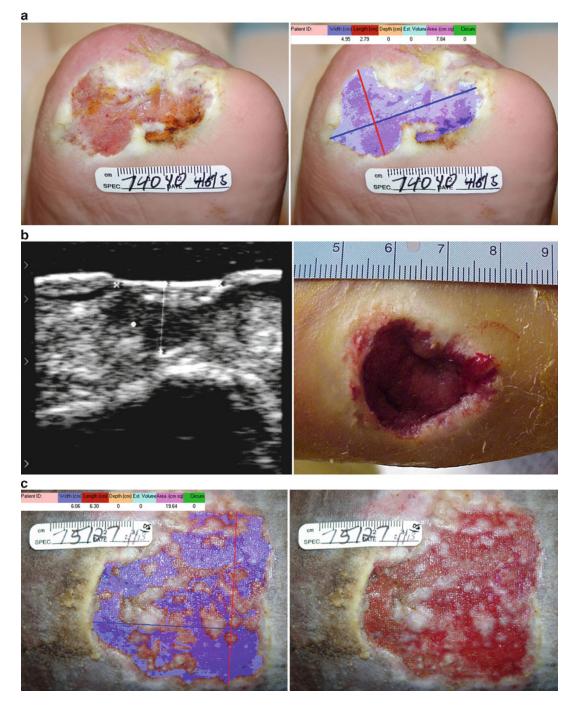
(a) Neuropathic foot ulcer measured on digital photographs using digital planimetry software. (b) High resolution ultrasonography provides noninvasive, objective, accurate measurements for deeper wounds and allows for examination of undermining and tunneling (*Reprinted from Wendelken, M, Markowitz, L, Patel, M, Alvarez, OM: Objective, noninvasive wound assessment*
